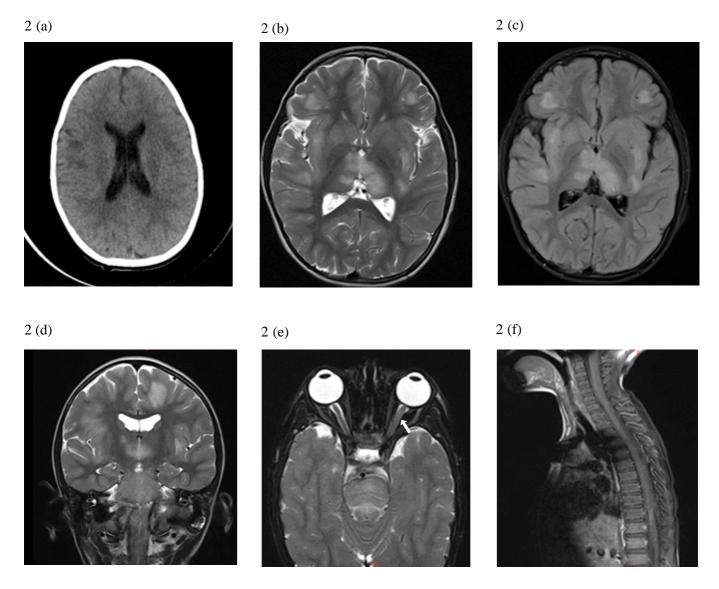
(a) CT scan showing a focal white matter hypodensity in the right frontal region. (b) T2-weighted MRI brain demonstrating high signal intensity areas involving the gray-white junction of both cerebral hemispheres, thalami, and right basal ganglia. (c) T2-FLAIR axial brain image showing changes in the grey-white junction of both cerebral hemispheres, thalami, and right basal ganglia. (d) T2 weighted coronal MRI demonstrating high signal intensities in the pons and cerebral peduncle. (e) There is a thickening and increased T2 signal in the left optic nerve (white arrow). The right optic nerve and chiasm appear normal (f) T2-FLAIR spine demonstrating no abnormalities.
